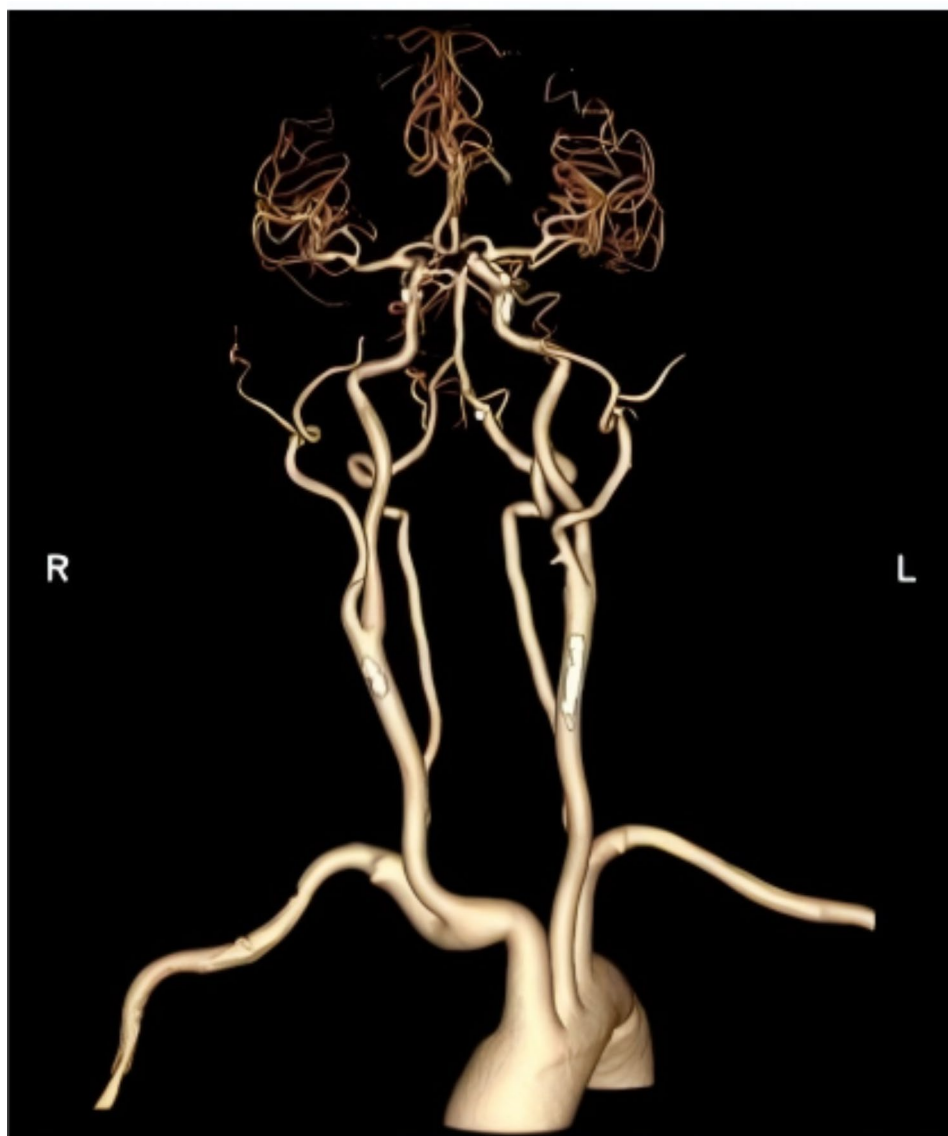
CTA imaging shows moderate stenosis in the M1 segment of the right middle cerebral artery
